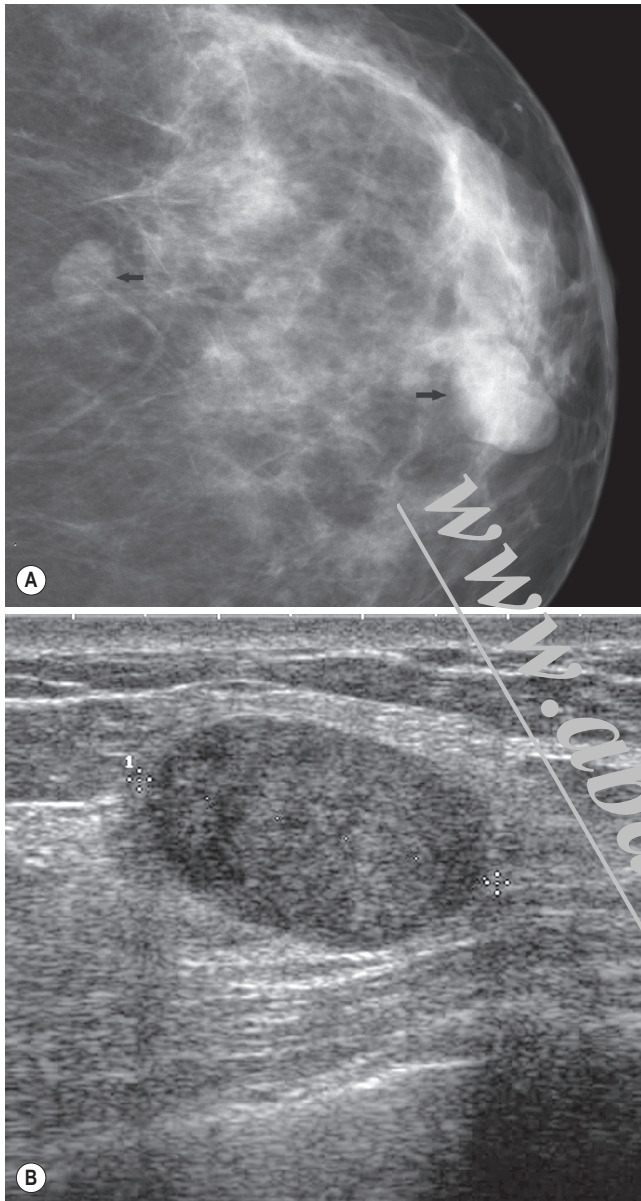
Fibroadenoma. (A) Two well-defined masses on mammography (*arrows*). (B) Ultrasound of the lesion nearer the nipple showed a well-defined oval mass. Both lesions were confirmed as fibroadenomas on ultrasound-guided core biopsy.
